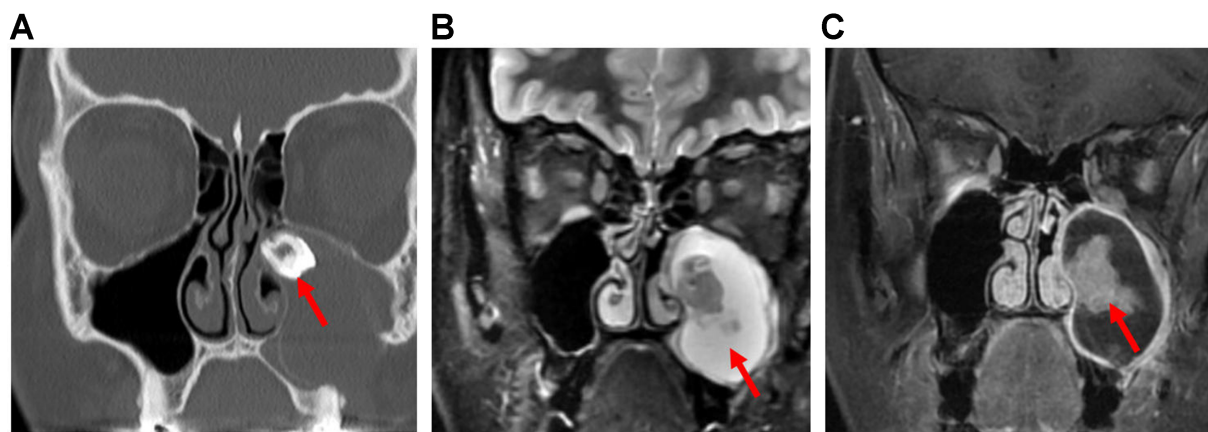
Ameloblastoma. (A) Coronal non-contrast CT image, (B) Coronal T2-weighted MRI, and (C) coronal post-contrast T1-weighted MRI show an expansile cystic mass (arrow, B) involving the left maxillary alveolus and extending into the left maxillary sinus. Avid enhancement of the internal solid component (arrow, C) is evident on the post-contrast MRI. The lesion is also associated with an unerupted tooth (arrow, A). CT: Computed tomography; MRI: magnetic resonance imaging.
